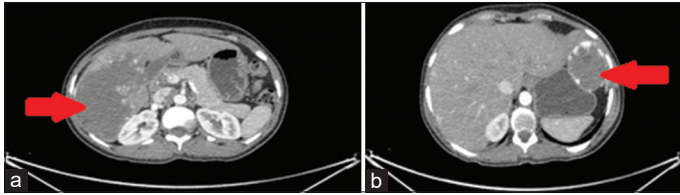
Computed tomography scan of the abdomen showing hemangioma of the liver marked with arrows. (a): Right lobe lesion, (b): left lobe lesion
